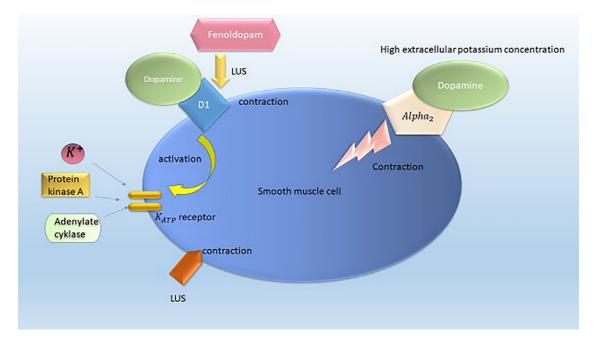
Effect of low-frequency ultrasound (LUS) on dopamine and fenoldopam vasomodulation via potassium channels.
